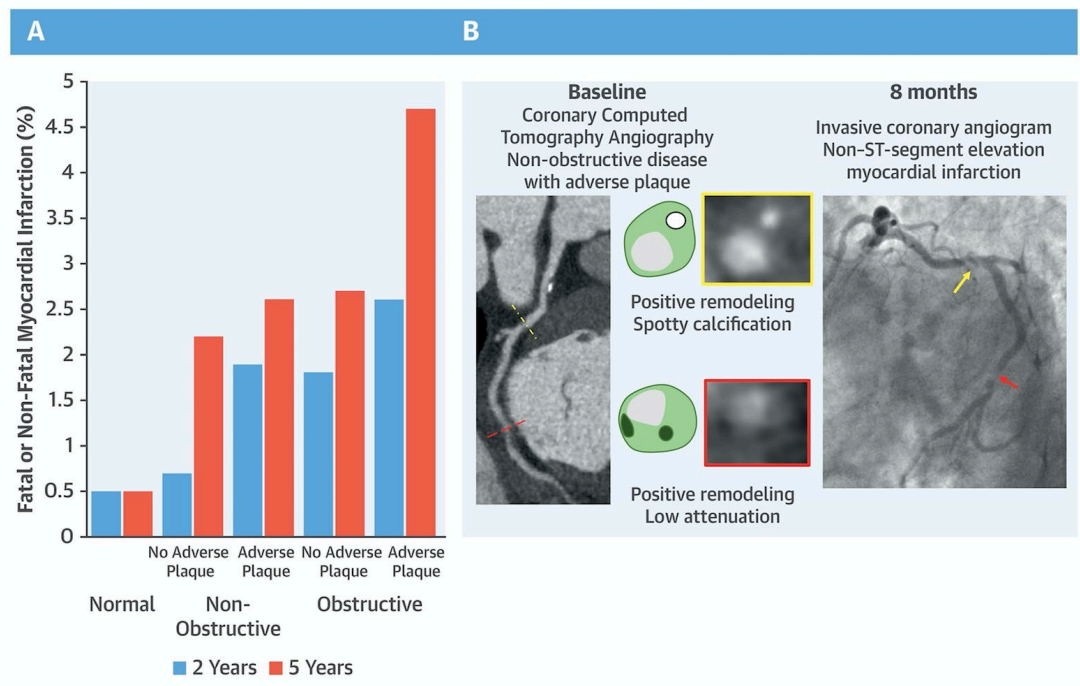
Adverse plaque features on coronary computed tomography angiography identifies patients at an increased risk of subsequent events.
